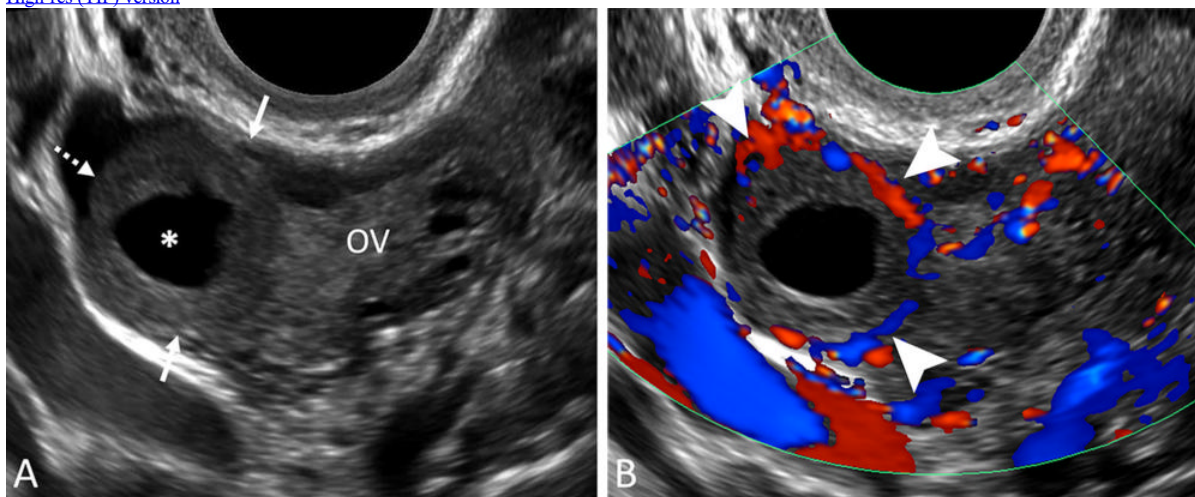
Corpus luteum. (A) Transvaginal sagittal grayscale and (B) color Doppler US image in a 31-year-old pregnant patient shows a round, hypoechoic, thick-walled structure (dotted arrow) with a central cystic space (*) and peripheral vascularity (arrowheads), characteristic of a *corpus luteum*. This corpus luteum arises in an exophytic fashion from the right ovary (OV), which can mimic a tubal ring of ectopic pregnancy. A helpful feature to diagnose a corpus luteum is a *claw sign* (solid arrows) of partially surrounding ovarian parenchyma, which confirms an ovarian origin.
